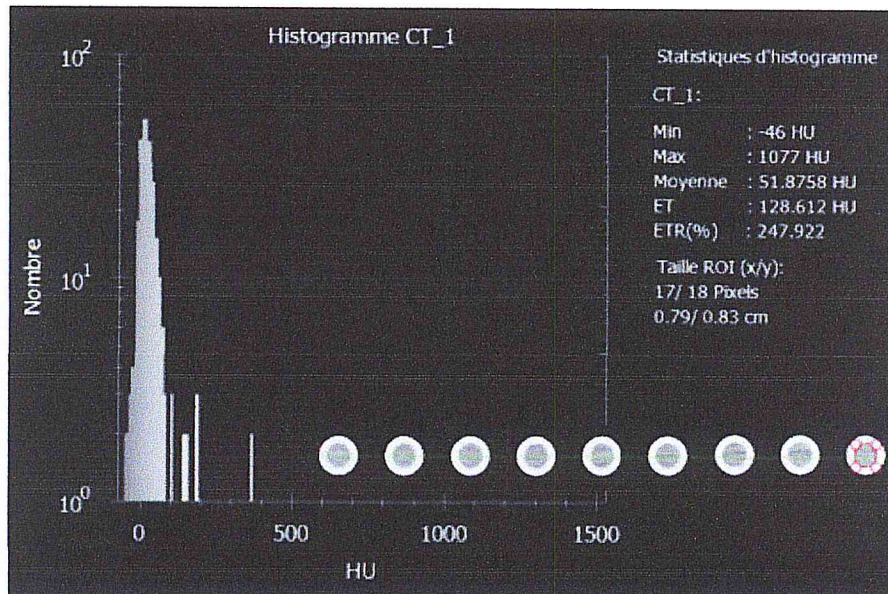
CT reading after irradiation
